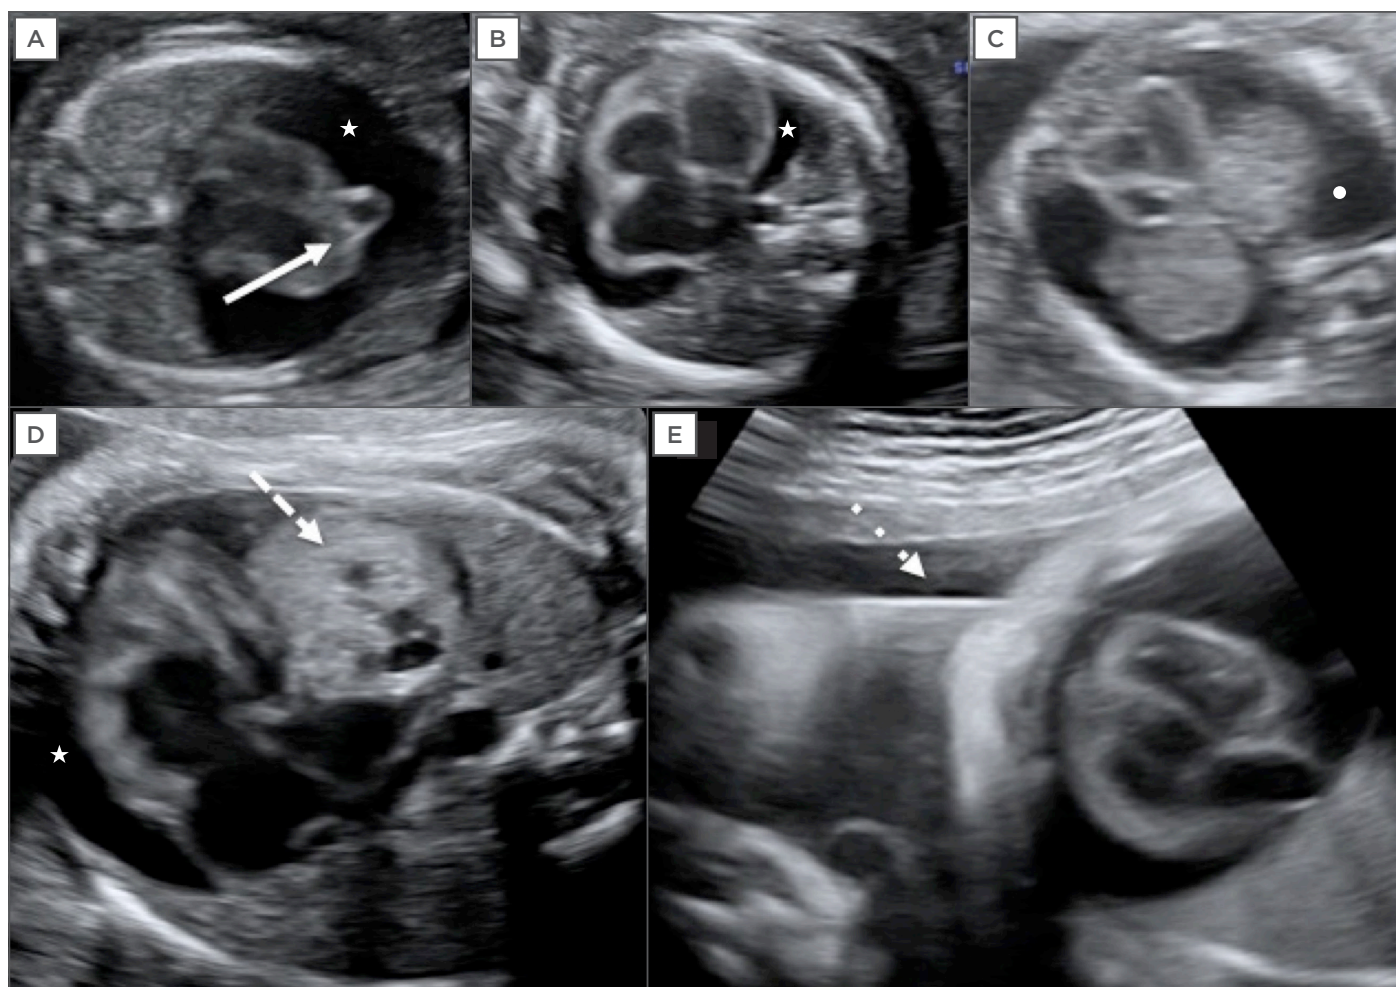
Fetal echocardiography.
